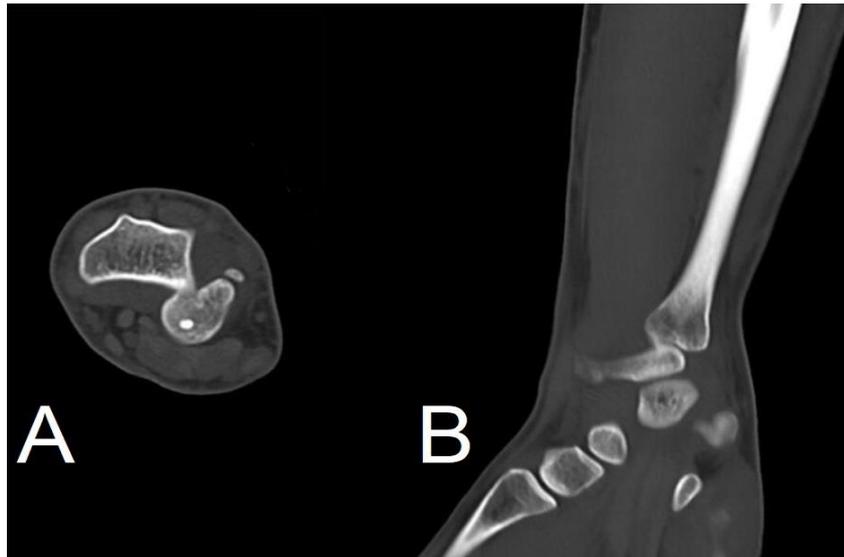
Axial (A) Coronal (B) CT-scans of the forearm
